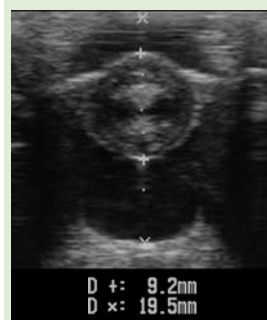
Lens swelling in a diabetic cataract demonstrated by ultrasound. The axial lens diameter here was 9.6 mm.
